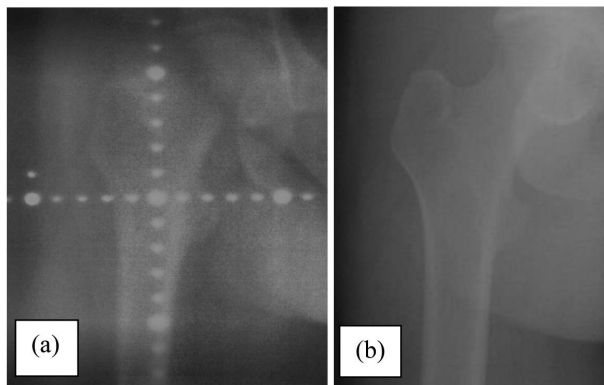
Comparison Between (a) MV and (b) KV Planar Images for the Right Leg. A Better Quality of Image Can be Made With KV X-Ray
